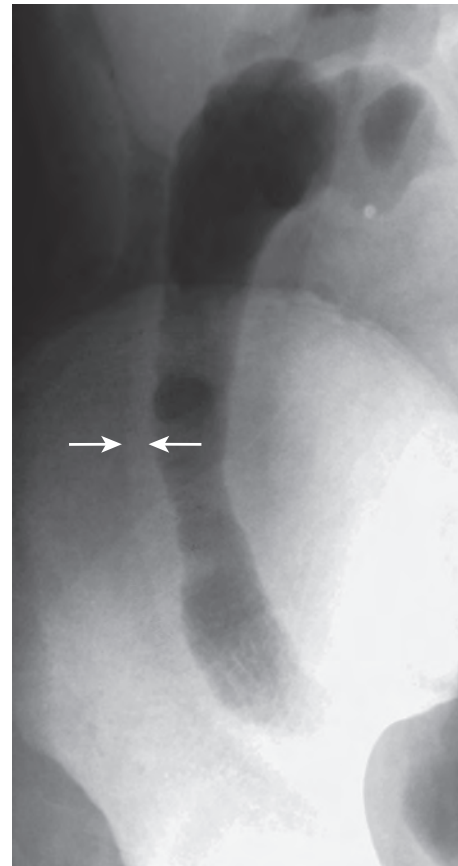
Crohn's disease: plain radiograph. The ascending colon is tubular and ahaustral. Note the mural thickening (arrows).
